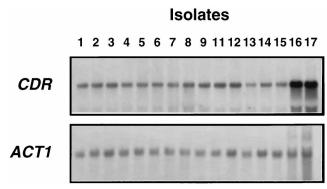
Northern blots probed with *CDR1*. Total RNA (20 μ g) from each isolate was electrophoresed through a formaldehyde agarose gel, blotted onto nitrocellulose, and probed with labeled DNA from *CDR1*. The blots were washed and exposed to X-ray film. Subsequently, the blots were rehybridized with a labeled probe for *ACT1*. The strong smearing in lanes 16 and 17 when the isolates were probed with *ACT1* is due to the *CDR1* signal that could not be removed before probing with *ACT1*.
